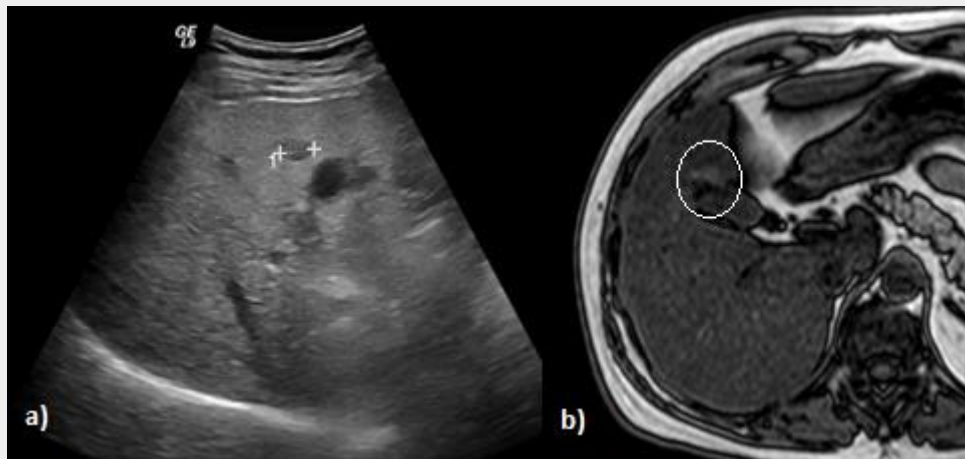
Patient with a small hypo echogenic nodule near the gallbladder fossa in ultrasound study (a); also note the diffuse parenchyma increased echogenicity. In MRI study no nodular lesion was found, except for a fat-sparing area near the gallbladder fossa seen in the T1-w out-of-phase imaging (b).
